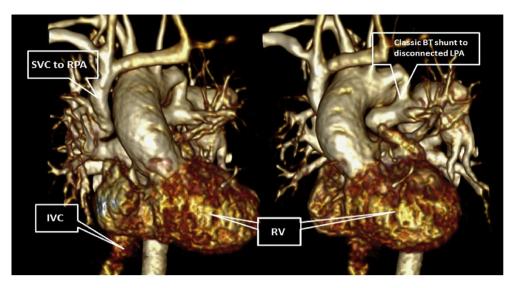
Magnetic resonance imaging (MRI) 3D reconstruction showing the anatomic details.
